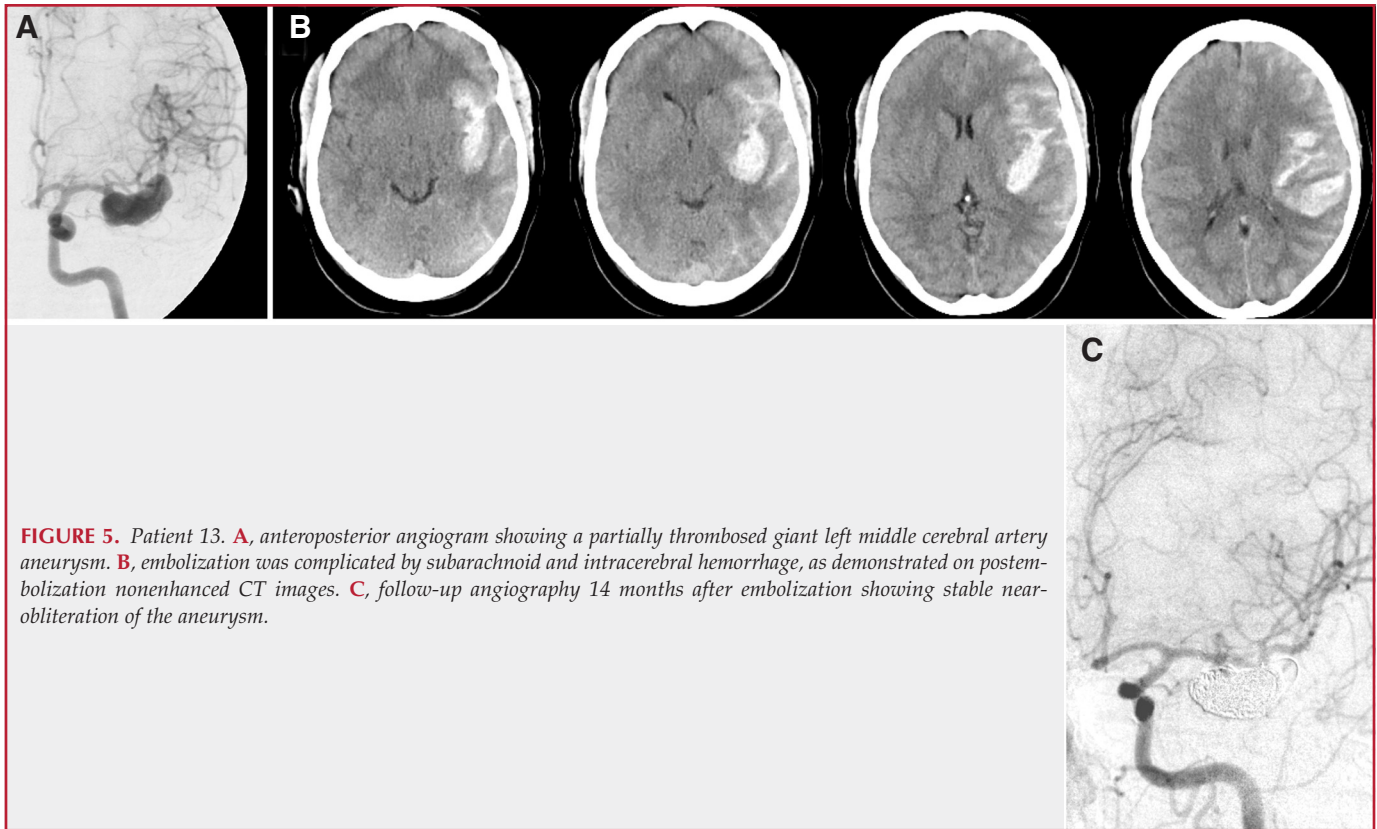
Patient 13. A, anteroposterior angiogram showing a partially thrombosed giant left middle cerebral artery aneurysm. B, embolization was complicated by subarachnoid and intracerebral hemorrhage, as demonstrated on postembolization nonenhanced CT images. C, follow-up angiography 14 months after embolization showing stable near-obliteration of the aneurysm.
